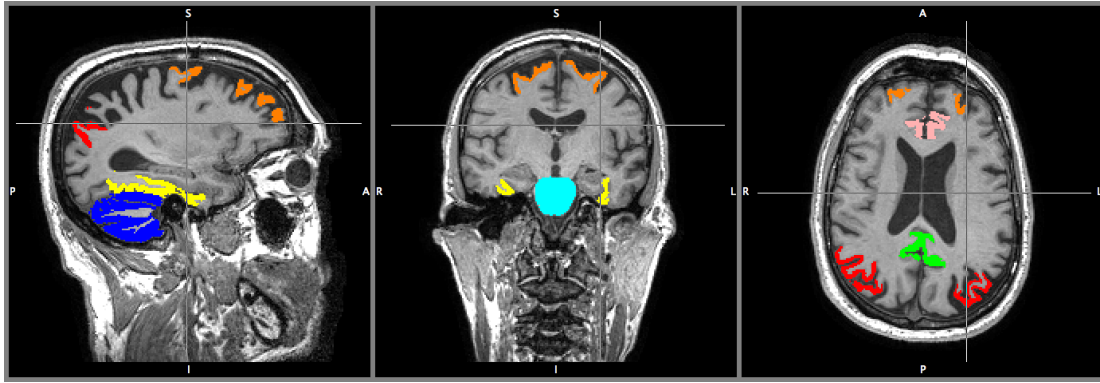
Regions used for the PET intensity normalisation and analysis. The pons (light blue), cerebellar grey matter (blue), angular gyrus (red), superior frontal gyrus (orange), fusiform gyrus (yellow), posterior cingulate gyrus (green) and anterior cingulate gyrus (pink) are superimposed on a T1-w MR image.
